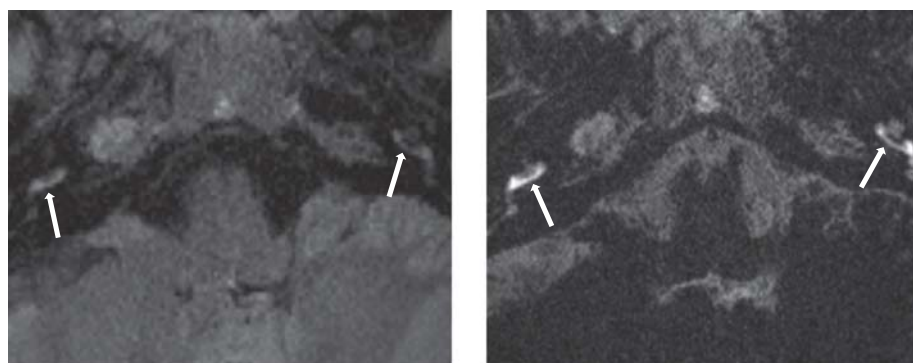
Images of the same slice of the basal turn of the cochlea enhanced after injection of the standard dose of Gd. The left image was taken using conventional 3D-FLAIR and the right image was taken using hT(2)W-3D-FLAIR. We obtained more information about the inner ear by using hT(2)W-3D-FLAIR than by using conventional 3D-FLAIR.
